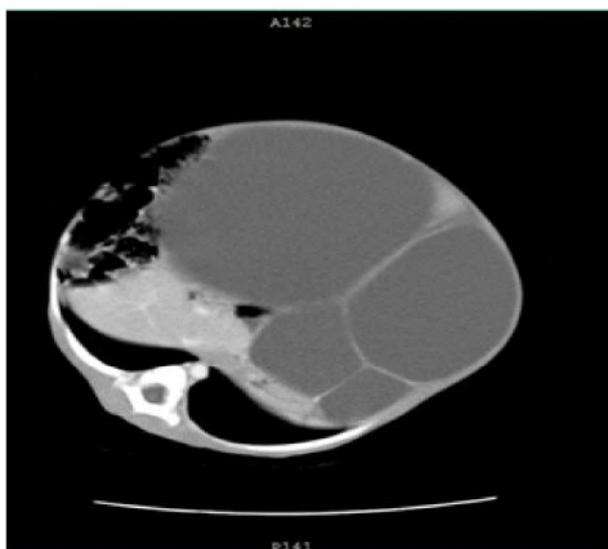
CT scan showing massive hepatic cyst with septations
